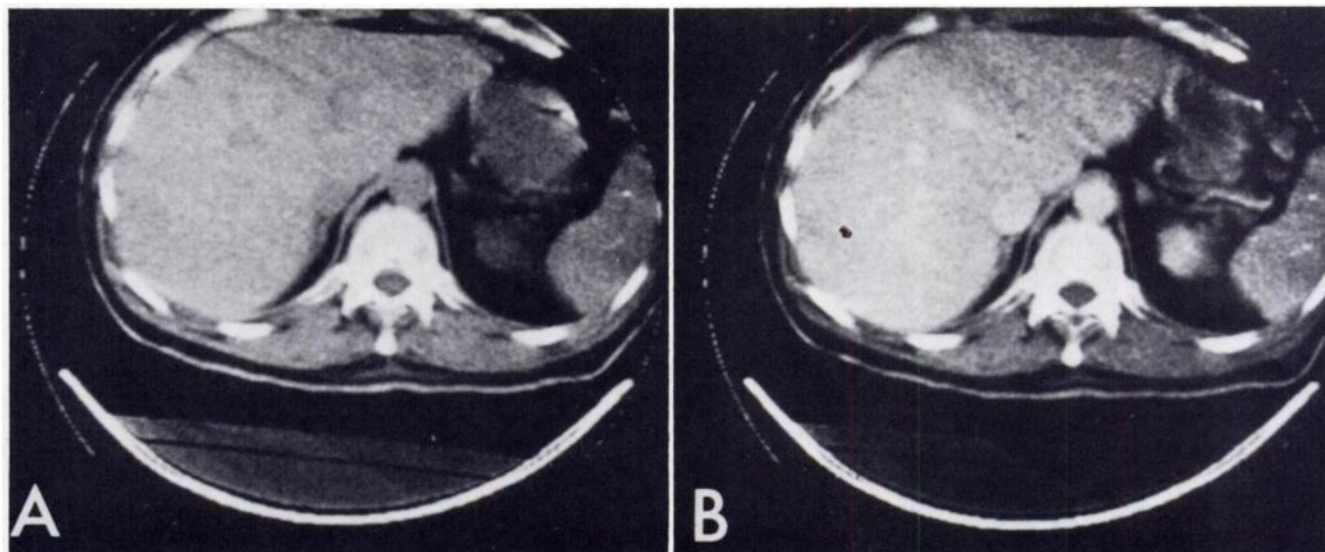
CT scans showing that small radiolucencies within liver on initial scan (A) are vessels since they become opaque after intravenous infusion of contrast material (B). Note also opacification of vena cava, aorta, and upper pole of left kidney.
